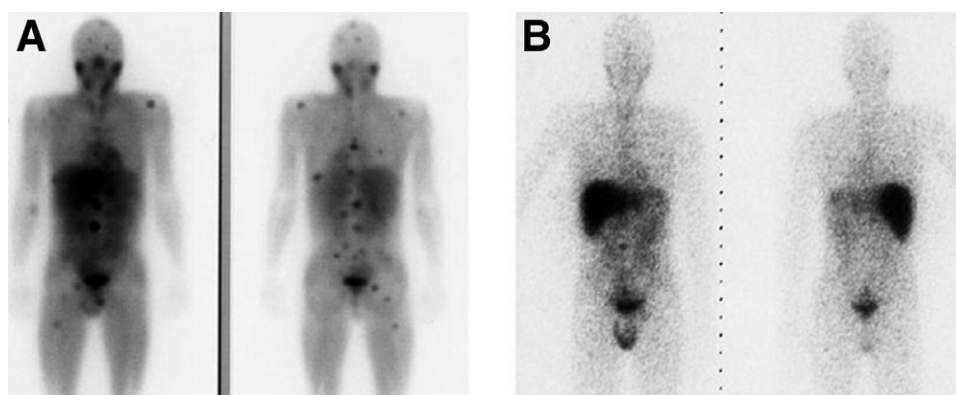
Drug interference with MIBG uptake in a patient with metastatic paraganglioma. (A) ^{131}I -MIBG scan following therapeutic dose shows uptake in the metastatic lesions. (B) Post MIBG therapy, the scan failed to detect the vast majority of metastatic lesions identified by FDG-PET. The most likely cause of this “false scan” is probably attributable to recreational drugs (such as cocaine, ephedrine) taken just before the recent MIBG therapy.⁸¹
